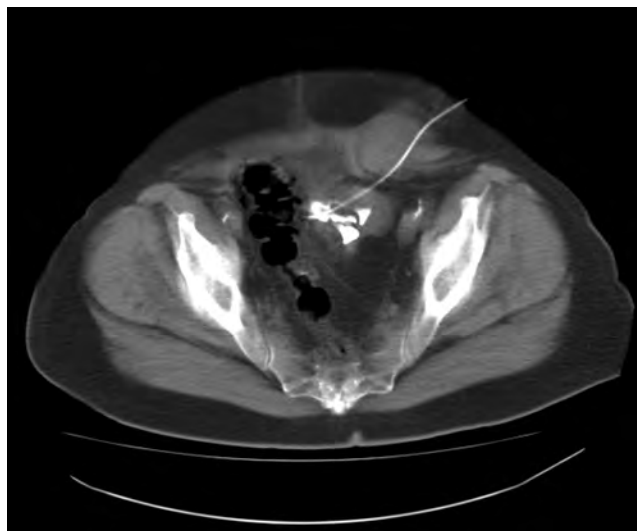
Computed tomography–guided percutaneous access of a renal transplant for subsequent percutaneous nephrolithotomy procedure.
